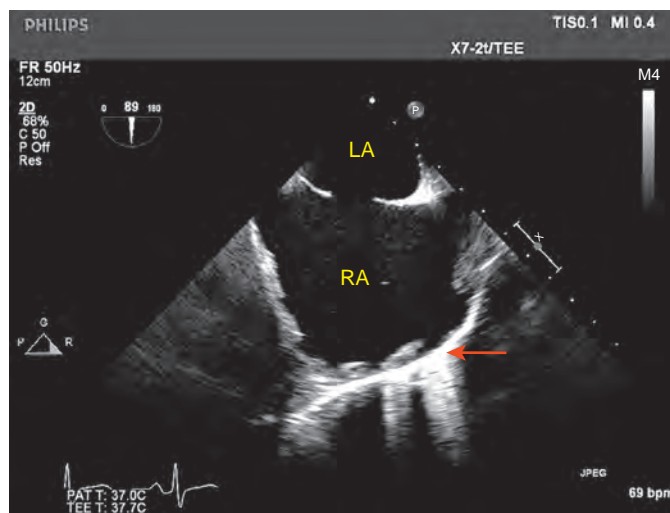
Midesophageal bicaval view of a patient with a secundum atrial septal defect. The large right atrium allows more ultrasound energy to penetrate deeper, causing enhancement of the deeper pericardium (red arrow). LA, Left atrium; RA, right atrium. (Video clip available online.)
